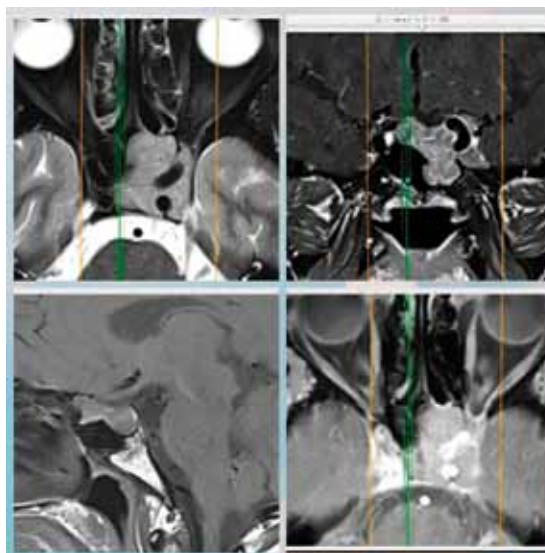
MRI-Brain & Orbit
